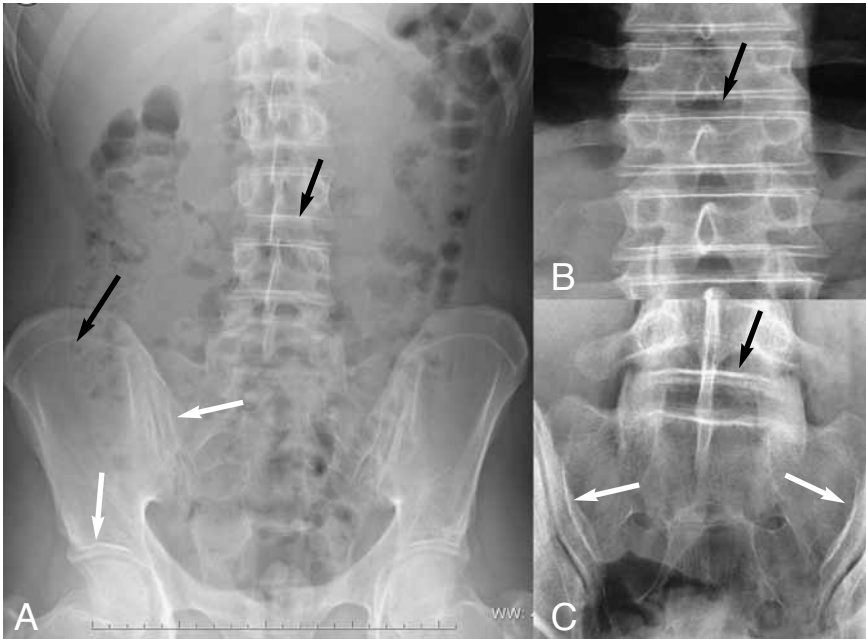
A to C: Postero anterior plain films of the lumbar spine (B). Vertebral bodies express the typical "vertebra-within-vertebra" configuration (small black arrows). Duplication of the bony cortex is also found at the level of the iliac crests (black arrow), acetabular roofs (white arrow) and sacroiliac joints (small white arrows).
